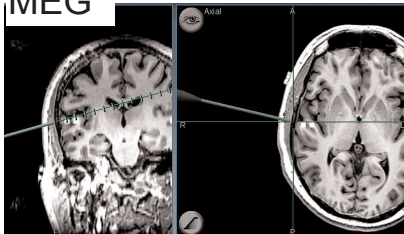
Patient #1's Surgical navigational MRI images with MEG tonotopic localizations for the 6,000 Hz and 8,000 Hz tones responses overlaid (grey squares; more medial square is the 8,000 Hz response).
